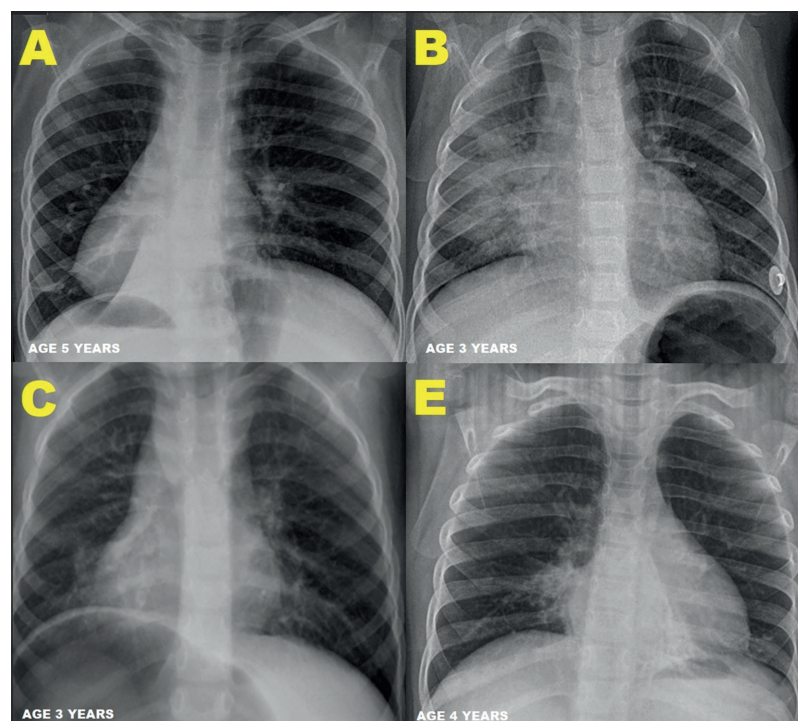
A (case 1, age 5 years): Chest X-ray shows situs inversus, accentuation of the right pulmonary hilum, with thickening of the right parahilar bronchial walls and right basal atelectasis. B (case 2, age 3 years): Chest X-ray shows consolidation opacities in the right hilar and parahilar region, with slight elevation of the right diaphragm. C (case 3, age 3 years): Chest X-ray shows situs inversus, faint right paracardiac consolidation, linear left paracardiac opacities. E (case 5, age 4 years): Chest X-ray shows right paracardiac consolidation, left basal retrocardiac atelectasis.
